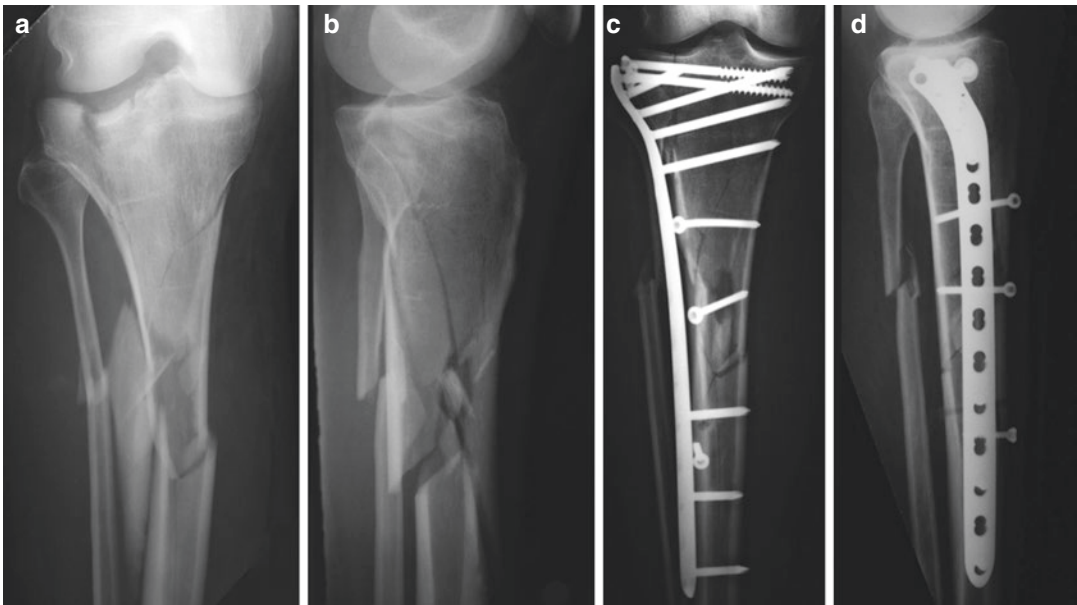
(a and b) Preoperative AP and lateral radiograph views of complex T-shaped fracture of the tibia plateau and diaphysis. (c and d) postoperative AP and lateral radiograph views of fracture osteosynthesis
